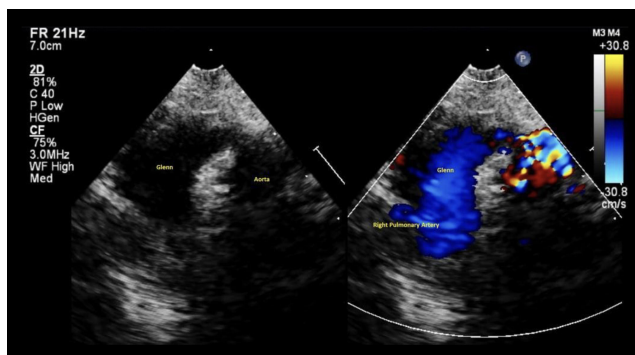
Glenn echocardiography
